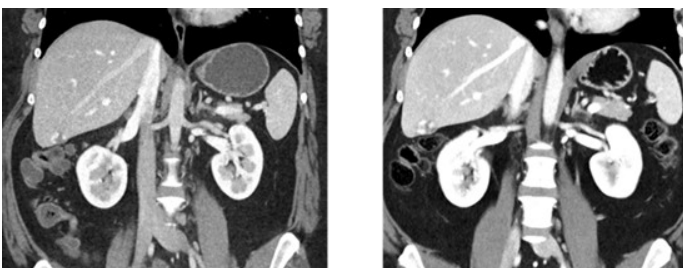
Same patient scanned with EID-CT (left) and PCD-CT (right), with enhanced contrast and CNR using PCD-CT.
